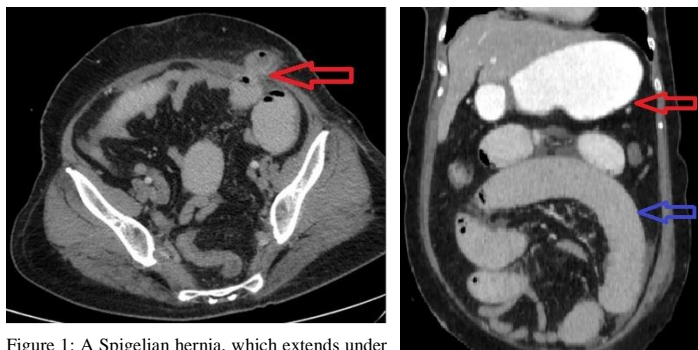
A Spigelian hernia, which extends under the skin from the lateral part of the left rectus muscle and contains the intestine, in the axial section of the abdominal CT scan.
